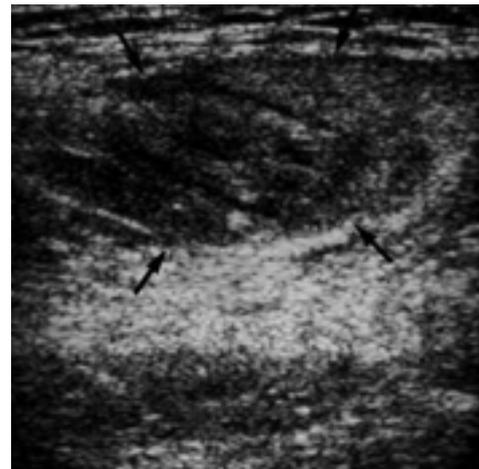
Transverse sonogram shows a relatively well demarcated, ovoid mass in the left pectoralis muscle with central linear echolucencies resembling dry and cracked mud (arrows).
